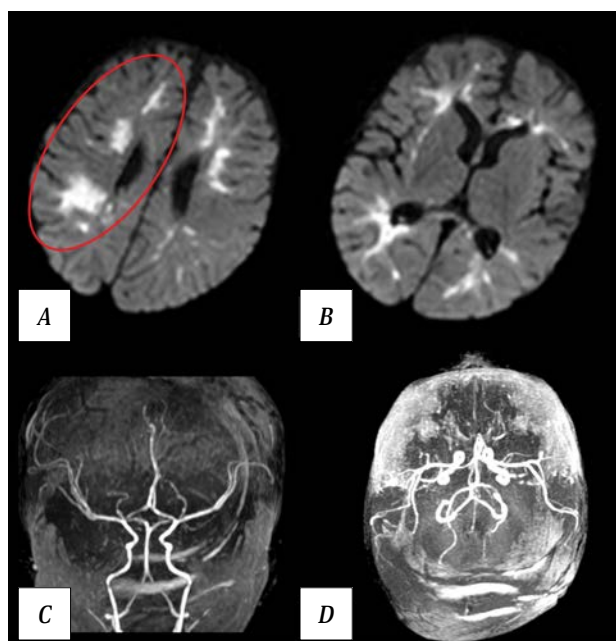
Results of patient B. MRI on day 2 postoperatively.
